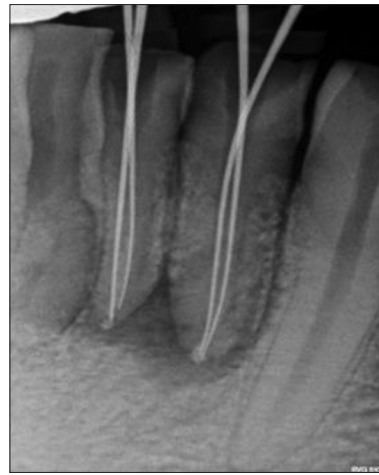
Working length radiograph showing two canals
